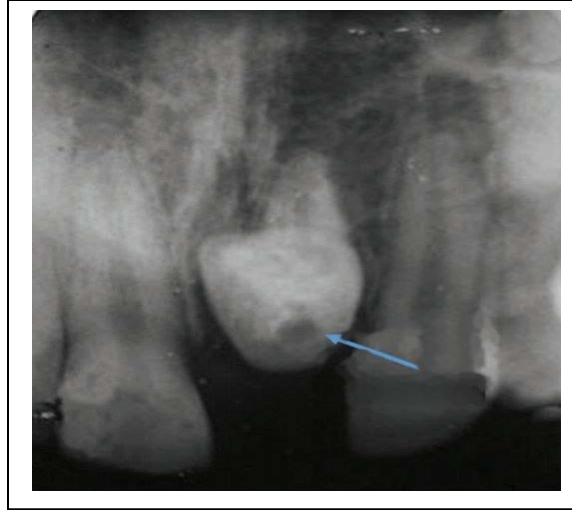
Periapical radiograph showing “Bulls Eye” phenomenon in a central incisor with dilacerated root (Pwanjit et al., 2016)
